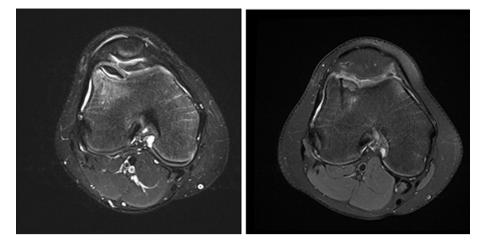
a: Pre-operative axial MRI image of an unstable OCD, 23 mm diameter, of the lateral femoral condyle. b: Axial MRI image of OCD at 28weeks post fixation with one of four bioabsorbable nails demonstrated.
